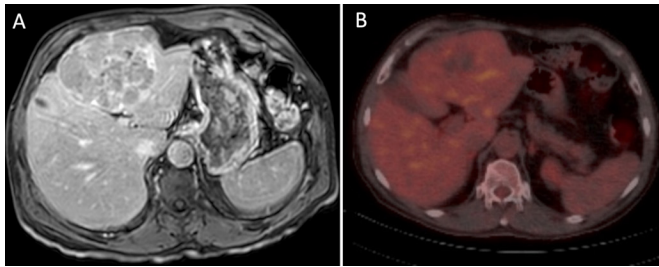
(A) Non-contrast CT and (B) positron emission tomography scan showing a large heterogenous hypodense mass in the liver and central area of photopenia related to necrosis at the junction of segments II and IVa, extending to segments II and III.
